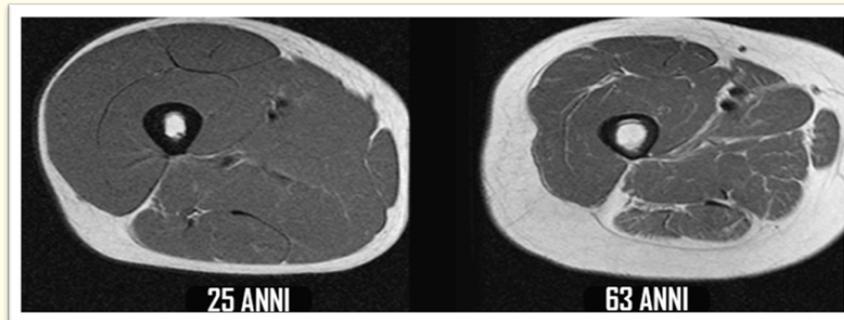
MRI of a muscle in a healthy 25-year-old and a 63-year-old sarcopenic subject.
